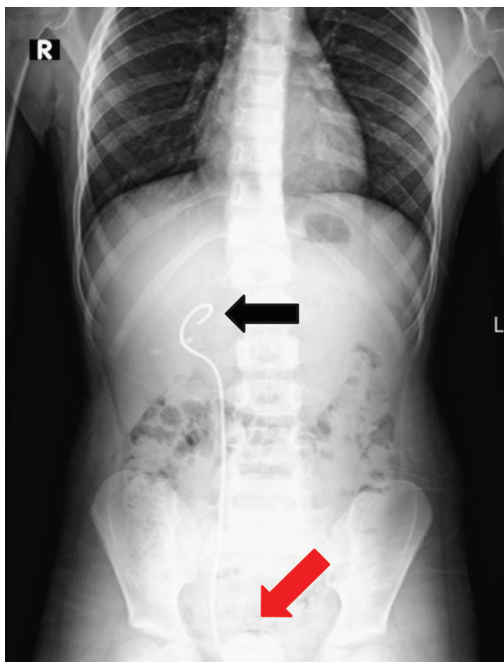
The radiograph of the patient's urinary tract. A double-J catheter placed in the right kidney (black arrow) and a kidney stone (red arrow).
